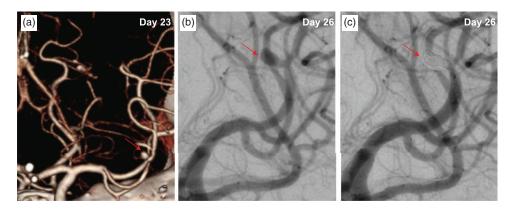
(a) 3D-CTA on day 23 showing an aneurysm at the M2/M3 bifurcation (arrow). (b) Cerebral angiography on day 26 showing the developed aneurysm (arrow). (c) Coil embolization was completed and there was no arterial flow into the aneurysm (arrow).
